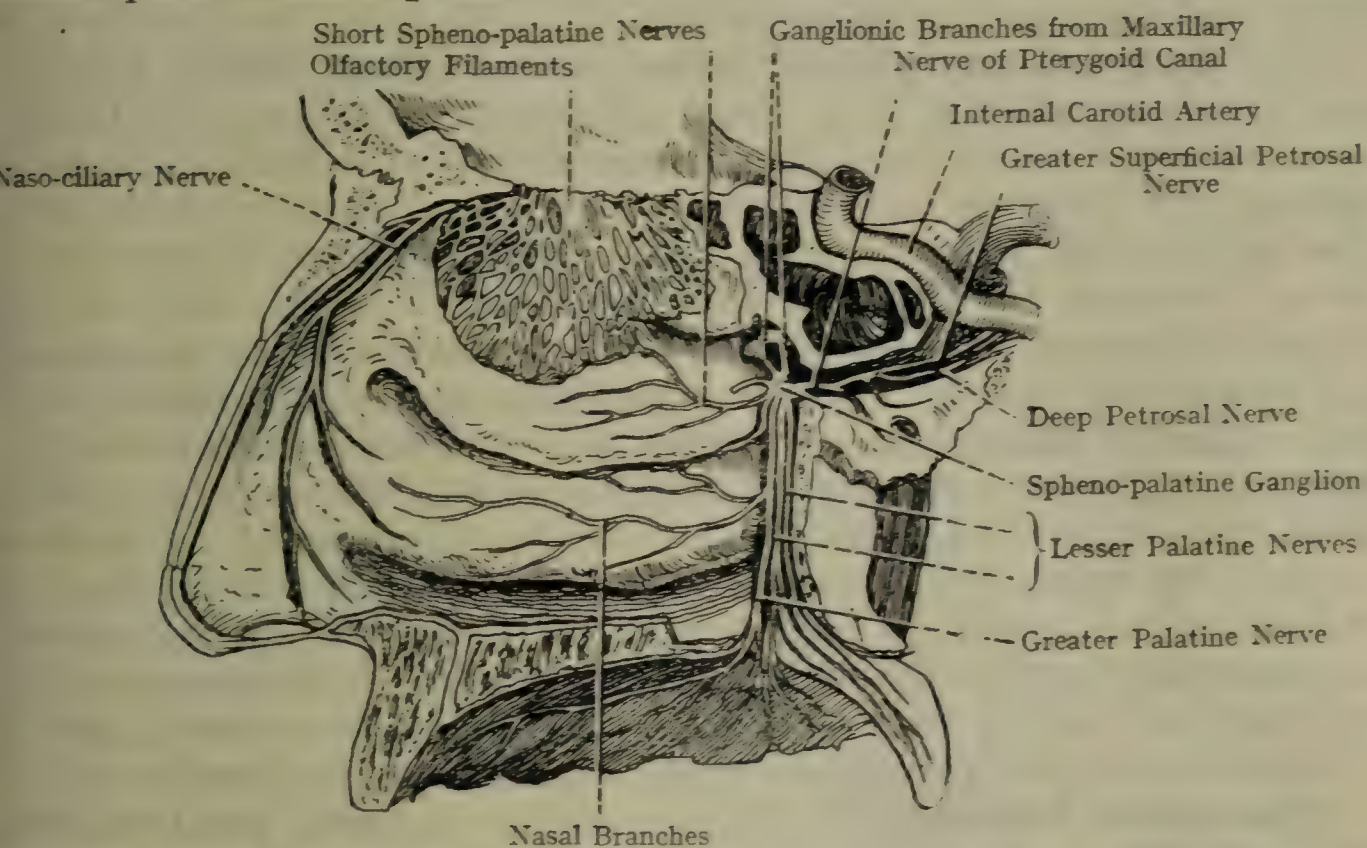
NERVES OF THE NASAL CAVITY, AND THE SPHENO-PALATINE GANGLION, WITH ITS BRANCHES (MEDIAL ASPECT) (HIRSCHFELD AND LEVEILLÉ).
